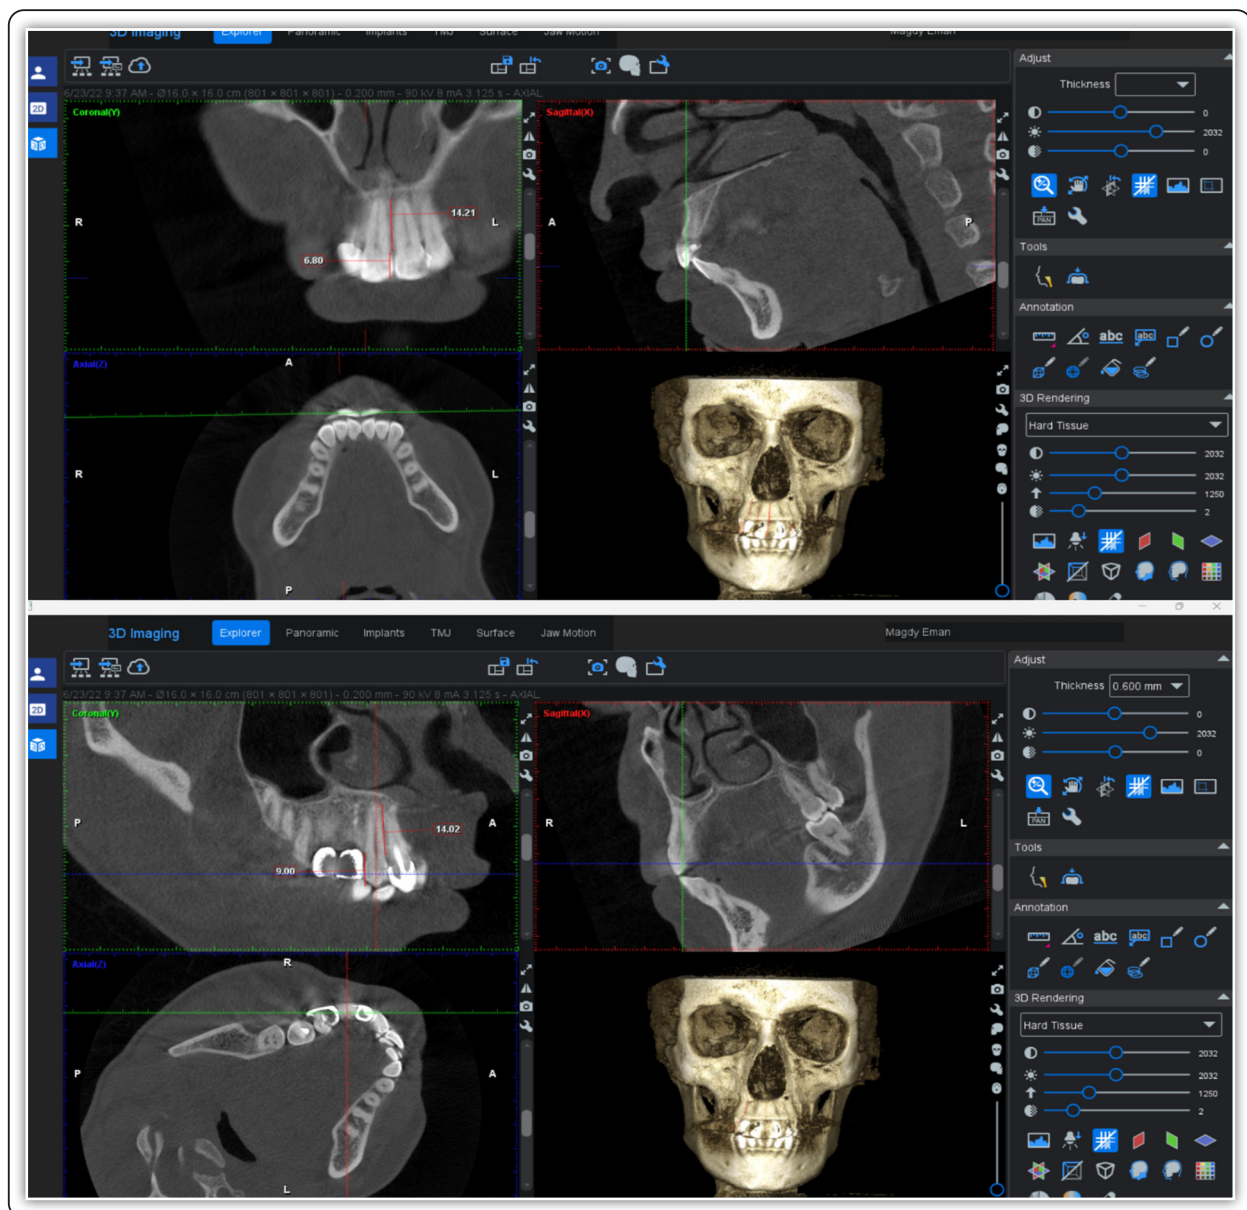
Crop of CBCT Measurements for Crown Root Ratio
